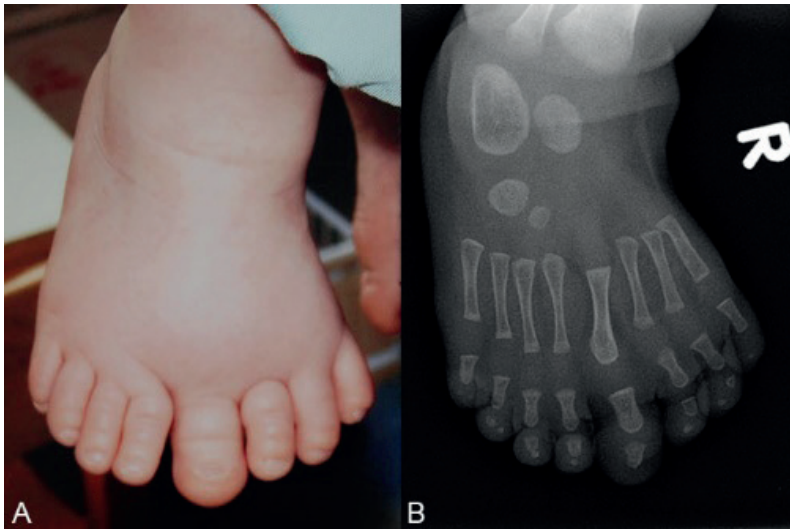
Preoperative view (a) and radiograph (b) of the right foot.
